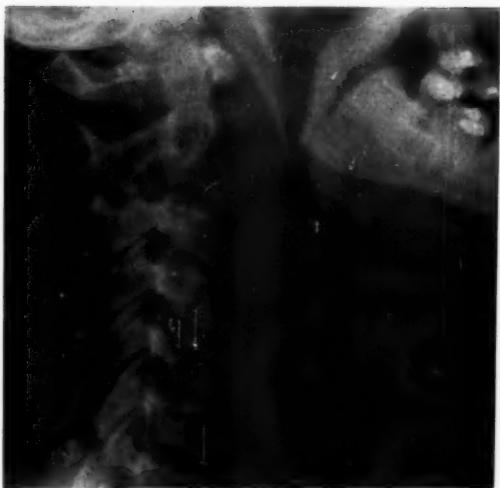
Lateral radiograph of neck: four days after original film. There is increased soft tissue swelling.
